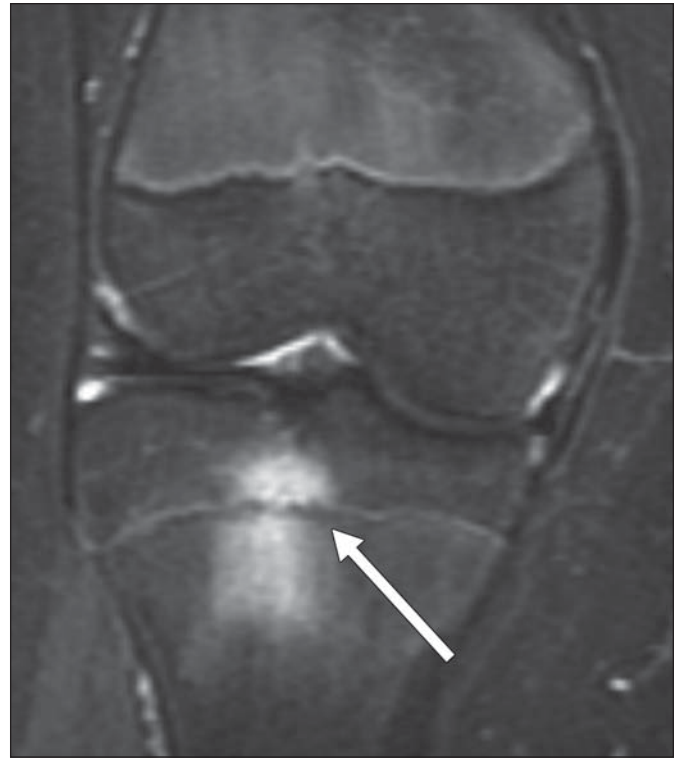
15-year-old girl with juvenile idiopathic arthritis and right lateral knee pain after injury 2 weeks earlier. Coronal fat-suppressed fast spin-echo T2-weighted image shows FOPE (focal periphyseal edema pattern) zone (*arrow*) with typical bone marrow edema pattern involving both central tibial metaphysis and epiphysis.
